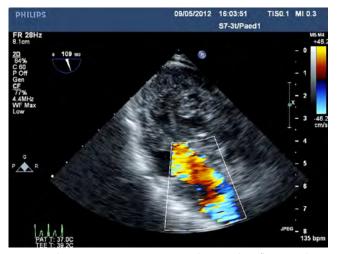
The same patient as in Figure 3. This 2D colour-flow Doppler image of the right ventricular outflow tract demonstrates good flow across this patient's pulmonary-systemic valve.
